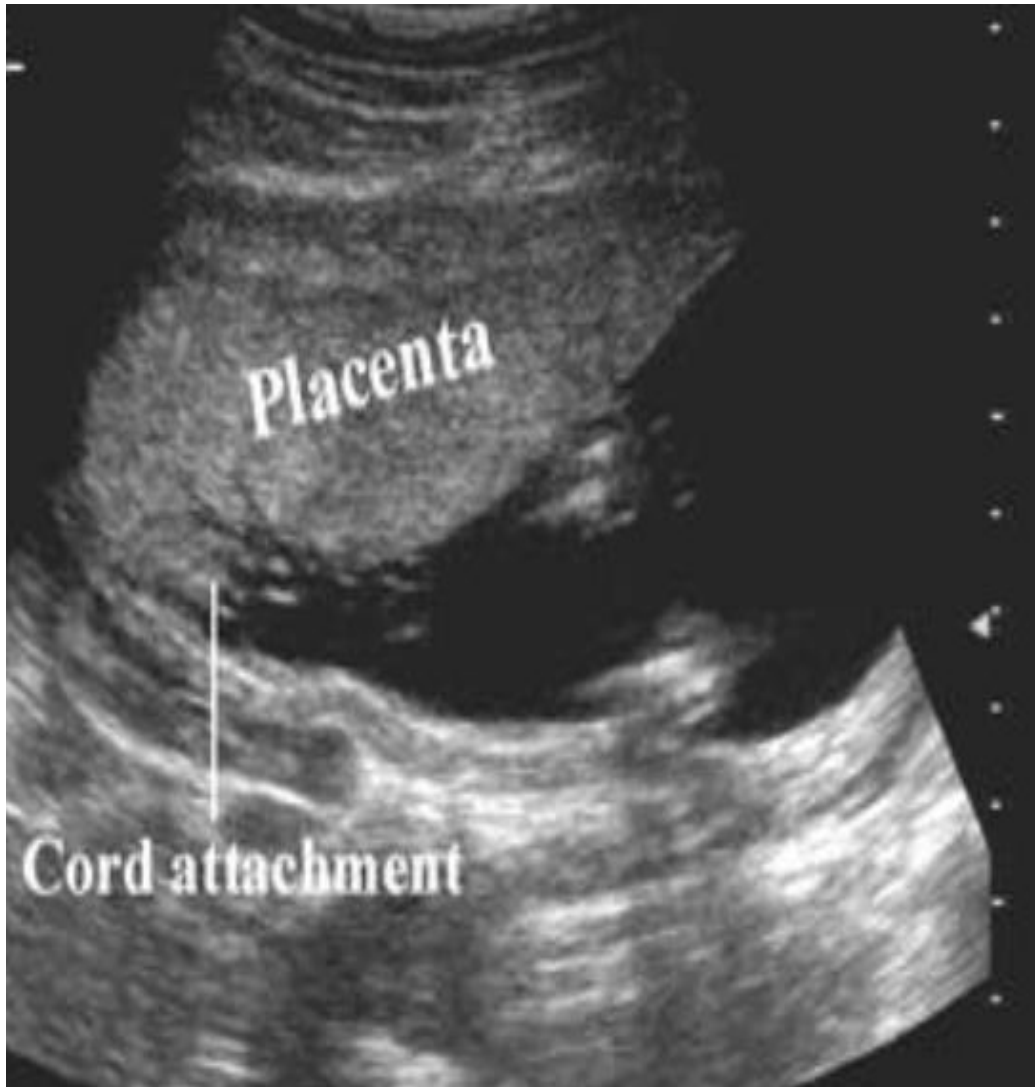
Sonographic appearance of placenta and umbilical cord attachment.
